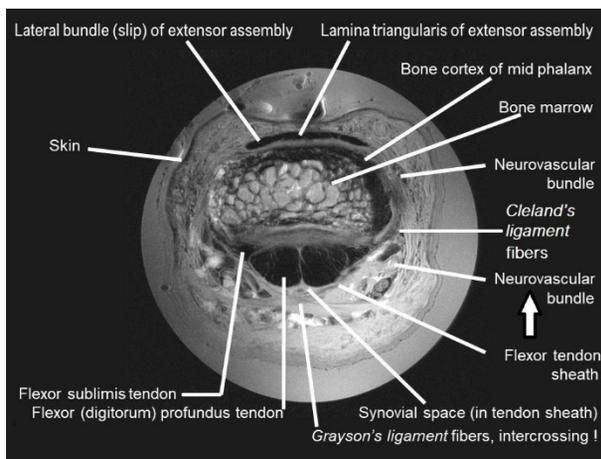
HR-MRI slicing, mid-phalanx level; ↑: palmar neurovascular bundle.
